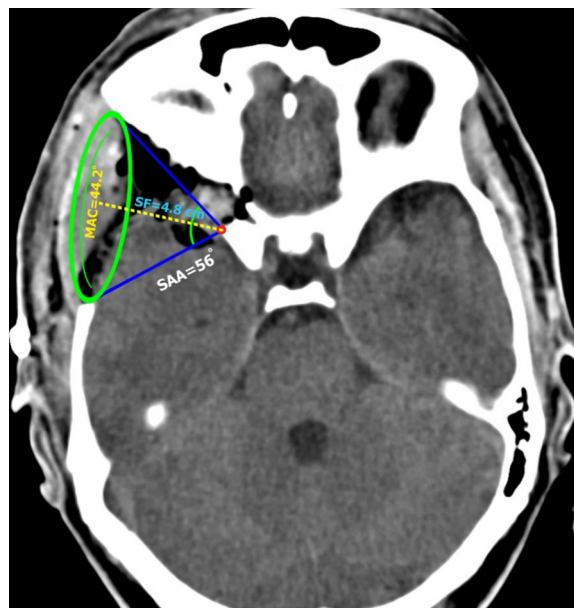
Postoperative non-contrast CT scan of the pterional approach without anterior clinoidectomy “PAAC-”, showing measurements of operability score parameters (MAC, SAA, SF)
